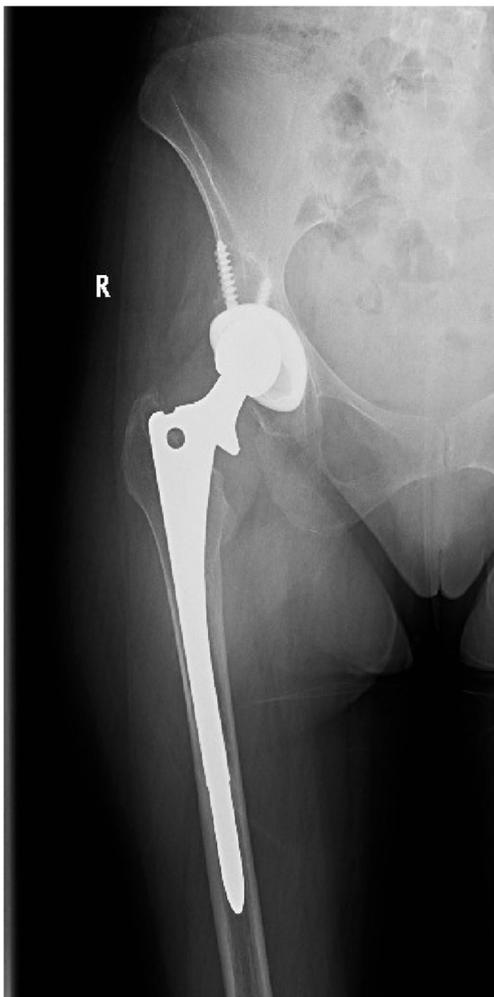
Patient 2 pre-operative x-ray of cup loosening
